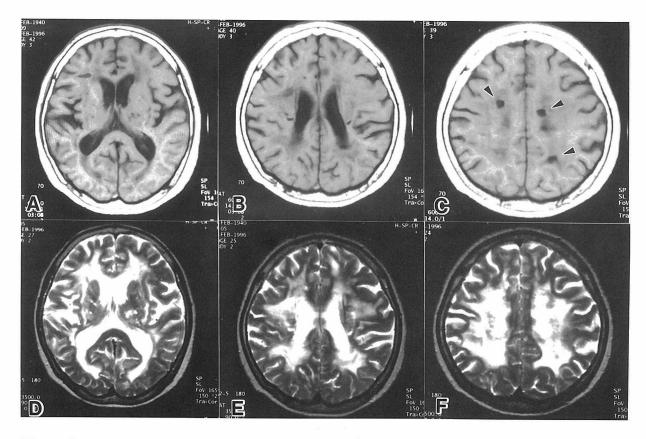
T1-weighted, axial spin-echo (SE) (TR 600/TE 14) images (A,B,C), and T2-weighted, axial SE (TR 3500/TE 90) images (D,E,F). T1-weighted images (A,B,C) show spotty abnormal hypo- intensity areas in the white matter and T2 weighted images (D,E,F) reveal diffuse abnormal hyper-intensity. T1-weighted images also show spotty low intensity areas in white matter consistent with old infarctions (arrowheads) (C).
